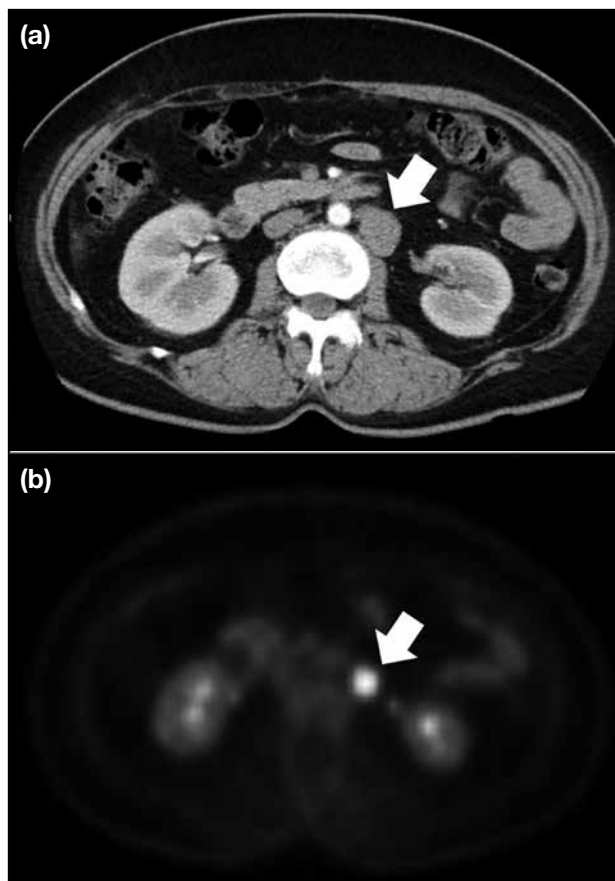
(a) Contrast enhanced computed tomography image demonstrating a solitary enlarged left para-aortic lymph node (arrow). (b) Further evaluation with positron emission tomography shows that this lymph node is hypermetabolic with standardised uptake value of 11 (arrow), suggestive of metastatic lymphadenopathy.
